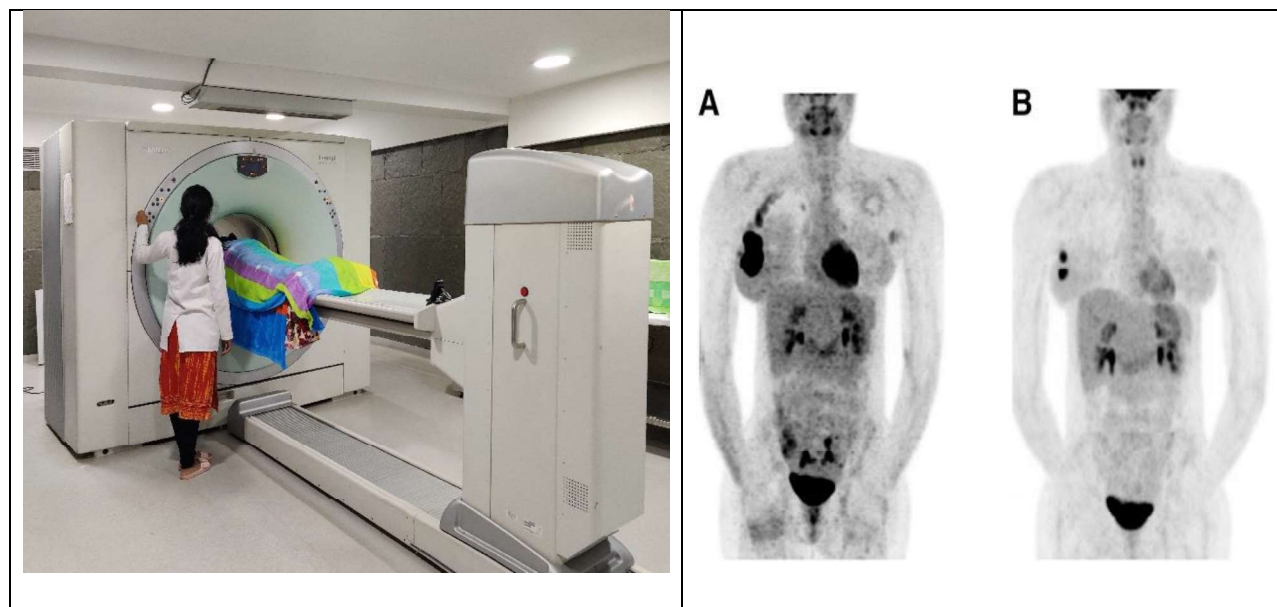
A patient undergoes a PET-CT imaging study (Left). The patient was injected with FDG and the images are acquired after an hour. The figure on the right shows the PET images of a patient before and after treatment. Significant reduction in the uptake of radioactivity is seen in the image on the right indicating that the tumour load has significantly reduced, an indication that the treatment is in the right direction.
